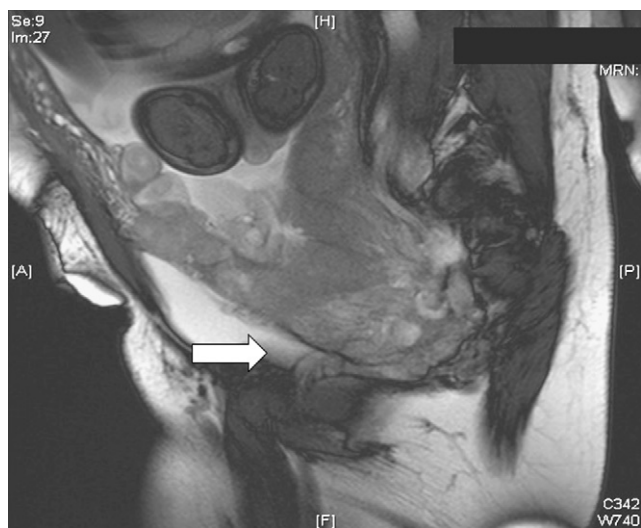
MRI of the placenta invading the bladder dome (white arrow). The dynamic images from the MRI depict no independent movement between the placenta and bladder, i.e. they move as one.
